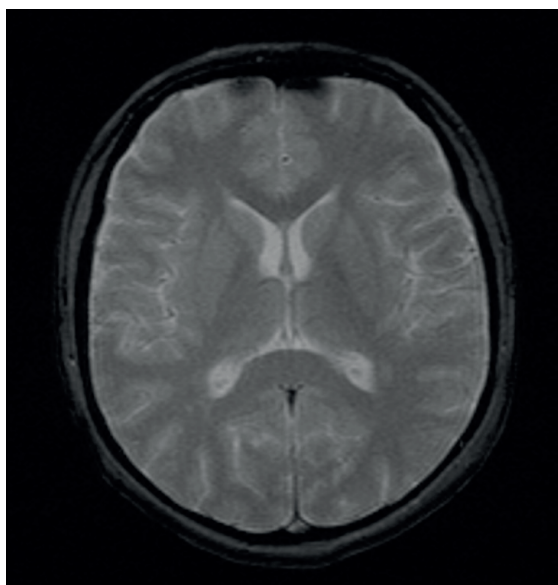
Cranial MRI Spect (Day 3). Brain MRI detects the low signal in T2 FLAIR hyperintense foci in the right frontal lobe deep white matter adjacent to the posterior horn of both lateral ventricles and the periventricular white matter.
